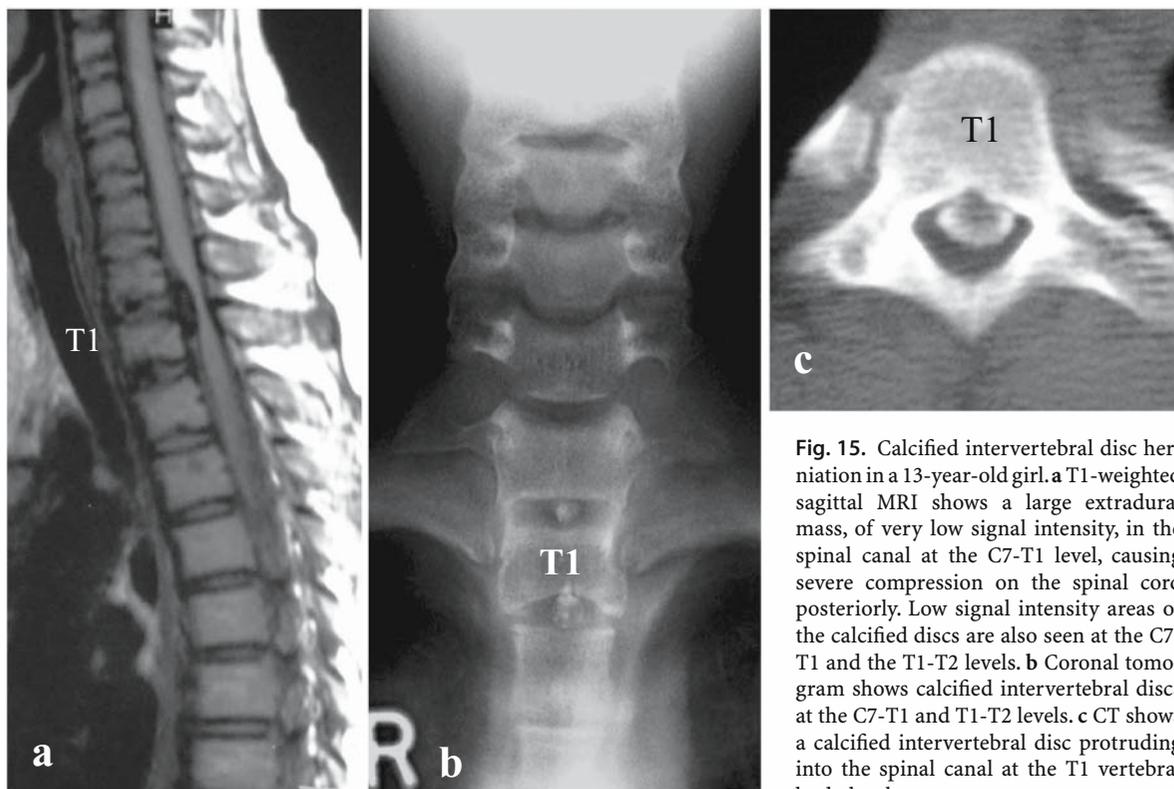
Calcified intervertebral disc herniation in a 13-year-old girl. a T1-weighted sagittal MRI shows a large extradural mass, of very low signal intensity, in the spinal canal at the C7-T1 level, causing severe compression on the spinal cord posteriorly. Low signal intensity areas of the calcified discs are also seen at the C7-T1 and the T1-T2 levels. b Coronal tomogram shows calcified intervertebral discs at the C7-T1 and T1-T2 levels. c CT shows a calcified intervertebral disc protruding into the spinal canal at the T1 vertebral body level
